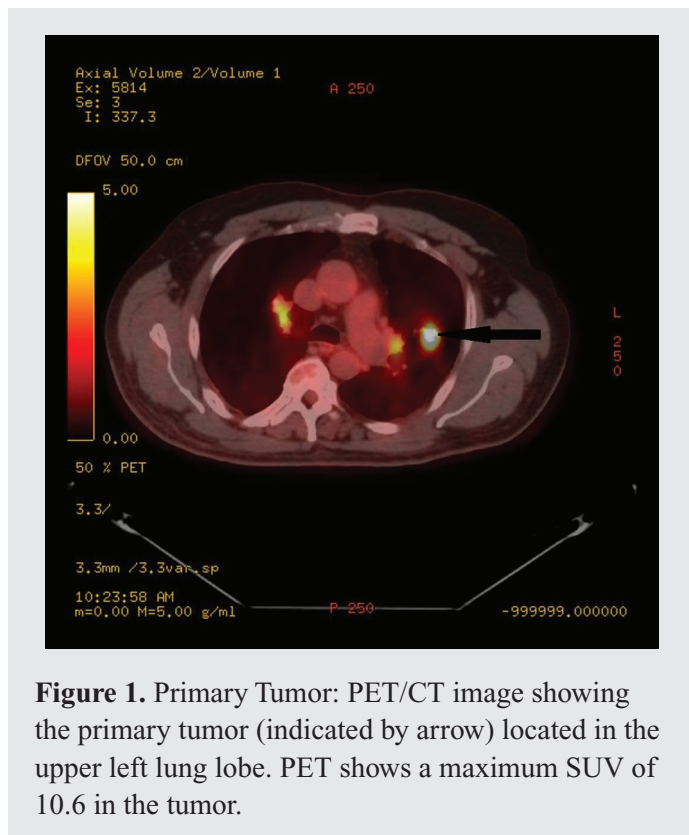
Primary Tumor: PET/CT image showing the primary tumor (indicated by arrow) located in the upper left lung lobe. PET shows a maximum SUV of 10.6 in the tumor.
